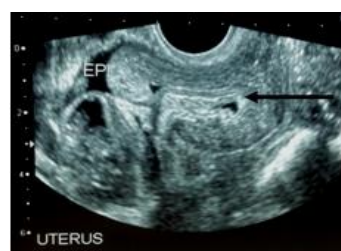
Endouterine ultrasound scan showing small intestine loop within the uterine cavity (→) and free fluid within the pouch of Douglas (←).
